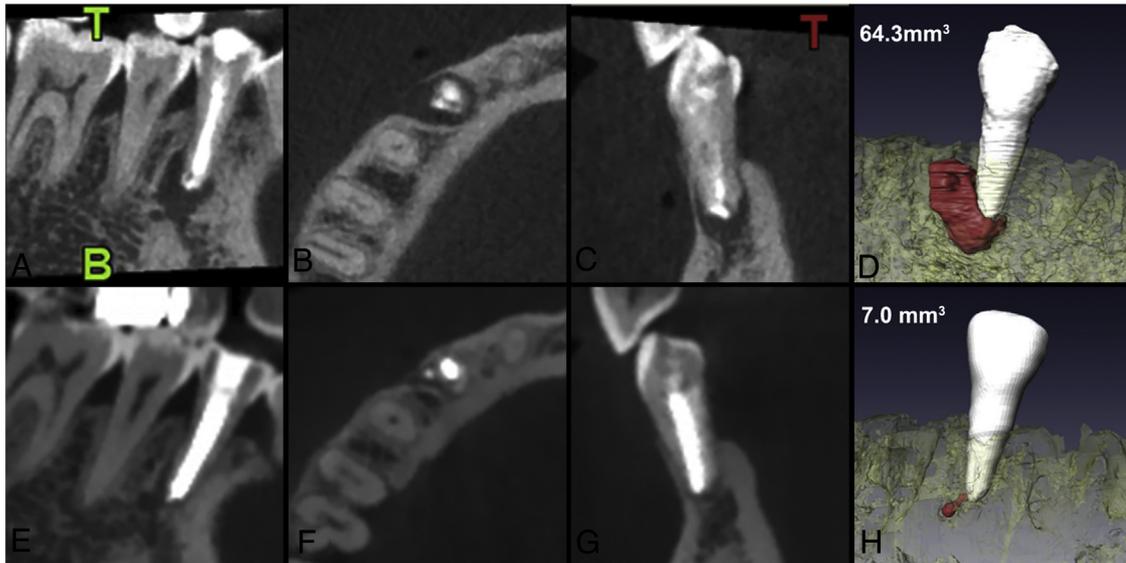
(A–D) A 32-year-old woman with a large periapical lesion on a mandibular first premolar as shown on the preoperative multiplanar and 3-dimensional reconstructed CBCT images. (A–C) The tooth was detected with an open apex, thin root walls, and a poorly obturated root canal preoperatively. After removing the previous root filling materials, the root canal was cleaned with a size #80 final apical file. Then, mineral trioxide aggregate was placed and compacted for apexification. (E–H) The postoperative CBCT images revealed the volume of periapical lesions significantly reduced from (D) 64.3 mm³ to (H) 7.0 mm³ at 4 years after treatment.
